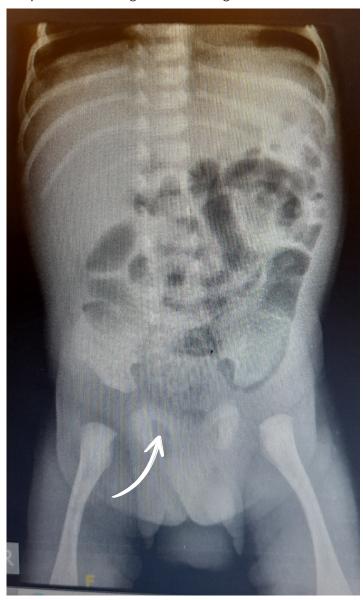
Plain radiography showing an image suggestive of gas in the right inguinal region (arrow).
